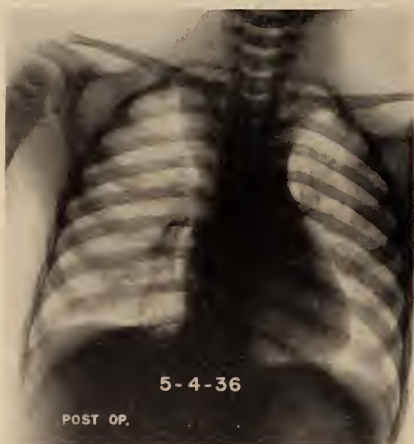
Roentgenogram of the chest, 2 years after operation, showing marked reduction in the size of the mediastinal mass, with the trachea in the midline.
